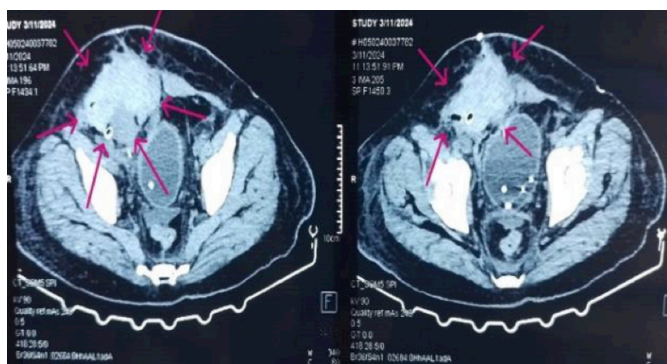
CT scan of abdomen and pelvis, arrows showing perigraft haematoma.
